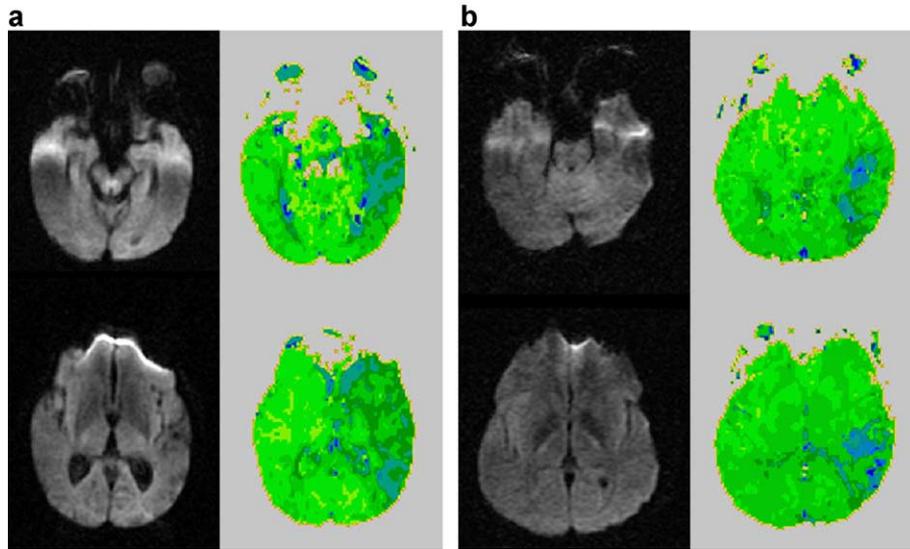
DWI and PWI scans from patients with impaired oral and written naming of objects and pictures and impaired oral reading but intact written word comprehension and lexical decision, with hyperperfusion of VWFA.
